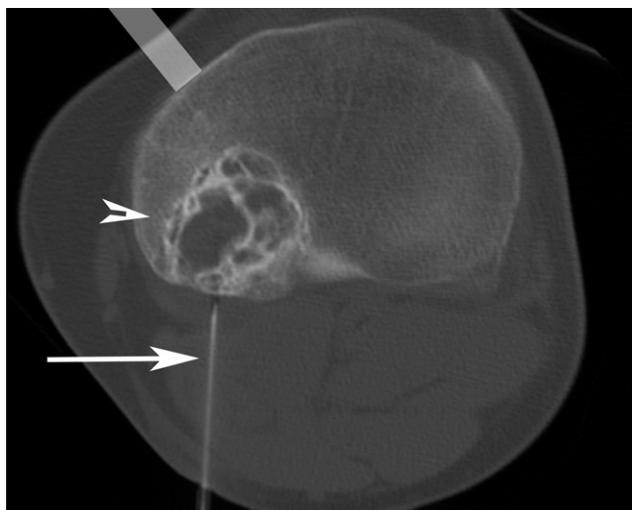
Location of the lesion and choice of biopsy path: axial CT of the proximal tibia. Lobulated bony lesion in the posterior tibial plateau with a thick irregular sclerotic margin and dense septations centrally (arrowhead); pathologic examination proved this to be chondroblastoma. The suggested path for the needle to take is overlying the anteromedial tibial cortex (shaded gray path), though adherence to this guideline would have significantly increased the difficulty level of the biopsy as it would require traversing thick intact cortex before the lesion, with a longer skin-to-lesion distance. Instead, a posterior approach was chosen (arrow marks the needle), allowing for direct entry into thinner abnormal cortex, where the lesion was abutting the posterior aspect of the tibial plateau.
